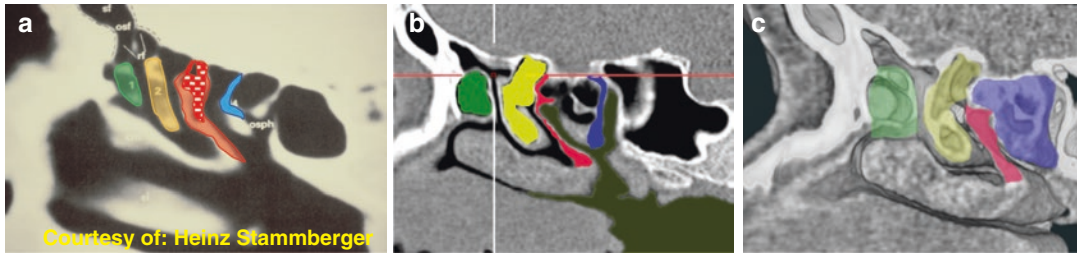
The lamellae within the ethmoid sinus. (a) Graphic display by H. Stammberger; (b) CT sagittal display; (c) 3D stereoscopic display. The color green outlines
